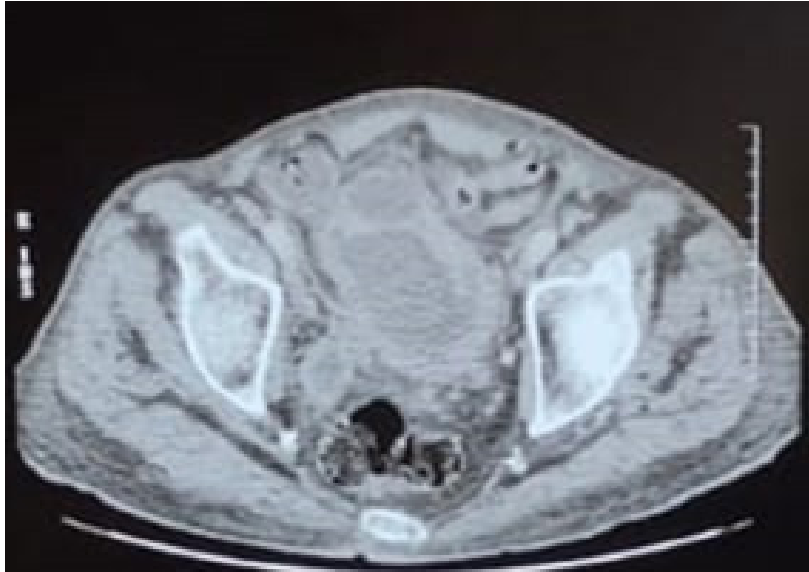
Axial pelvic CT scan showing circumferential thickening of the bladder wall with suspected infiltration and a diverticulum of the bladder dome.
